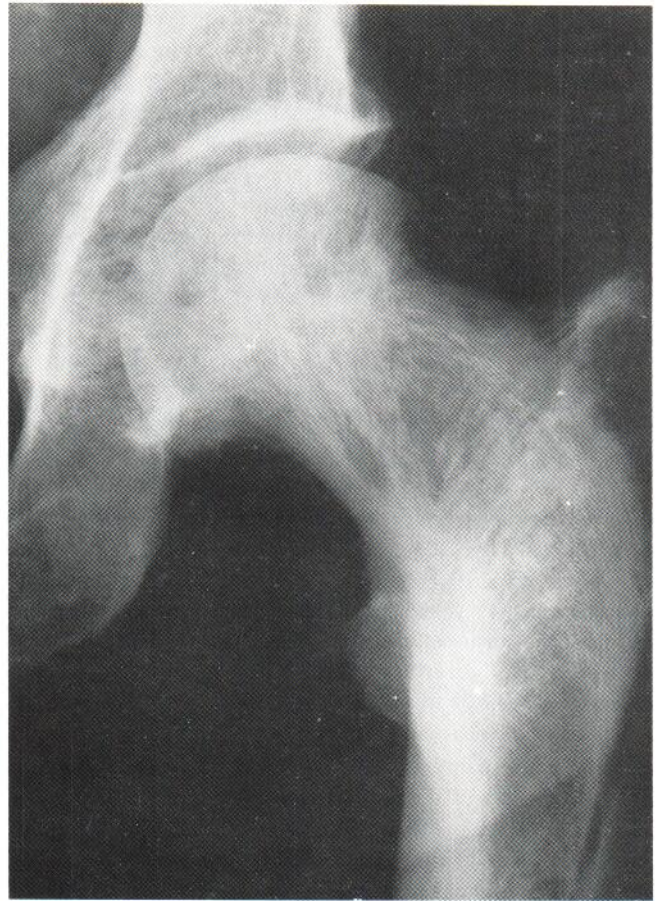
X-ray of the neck of femur with osteocondensation and patchy hypodensities.
